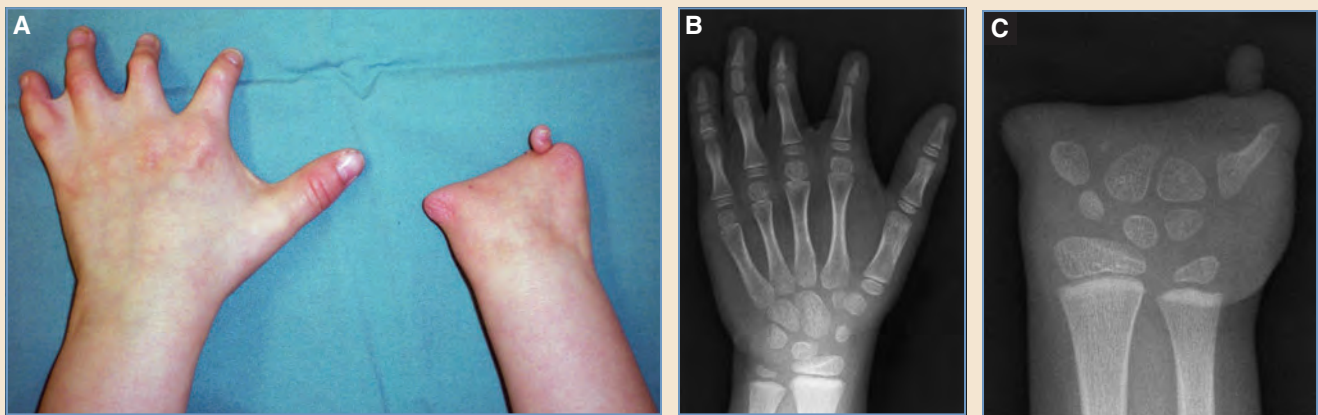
Bilateral symbrachydactyly. A, Diphalangal type on the left and acarpia type on the right, as classified by Yamauchi and Tanabu. These would be classified as short finger type on the left and peromelia on the right in Blauth and Gekeler's classification system. B, Posteroanterior radiograph of the left hand. C, Posteroanterior radiograph of the right hand.
